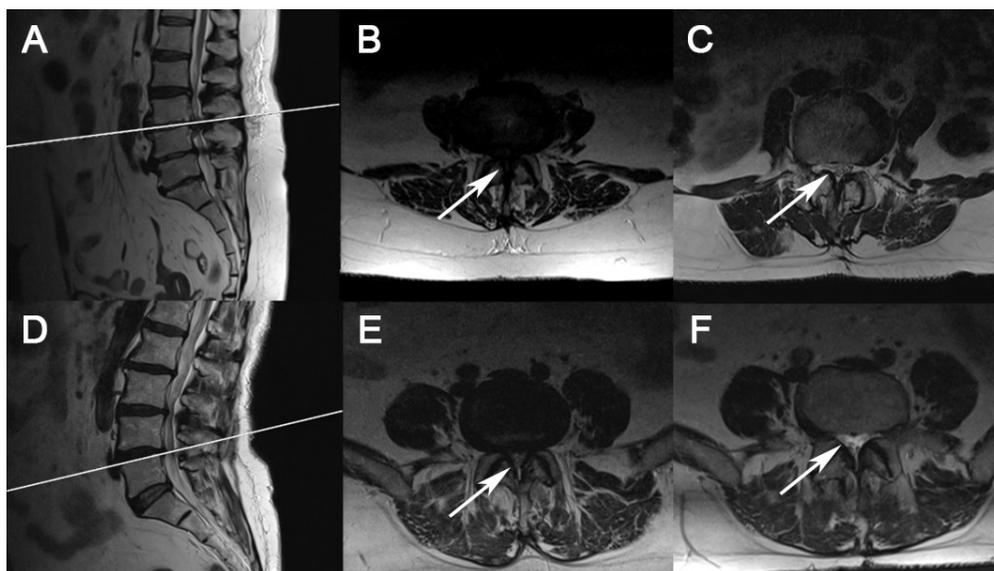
Preoperative and postoperative MRI of the lumbar spine. Patient 1. A) Sagittal T2-weighted MRI showing lumbar spinal stenosis (LSS) at L3/L4 and L4/L5, treated with two-level laminectomy; B) preoperative axial MRI demonstrating Schizas grade D stenosis (arrow); C) postoperative axial MRI at 6 months showing restored rootlets and cerebrospinal fluid space (arrow). Patient 2. D) sagittal MRI of a patient with LSS at L4/L5; E) axial MRI demonstrating Schizas grade C stenosis (arrow); F) postoperative axial MRI at 6 months showing successful decompression with visible rootlets and cerebrospinal fluid space (arrow).
